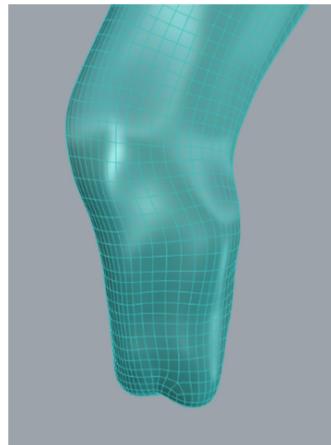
3D stump model from MRI
